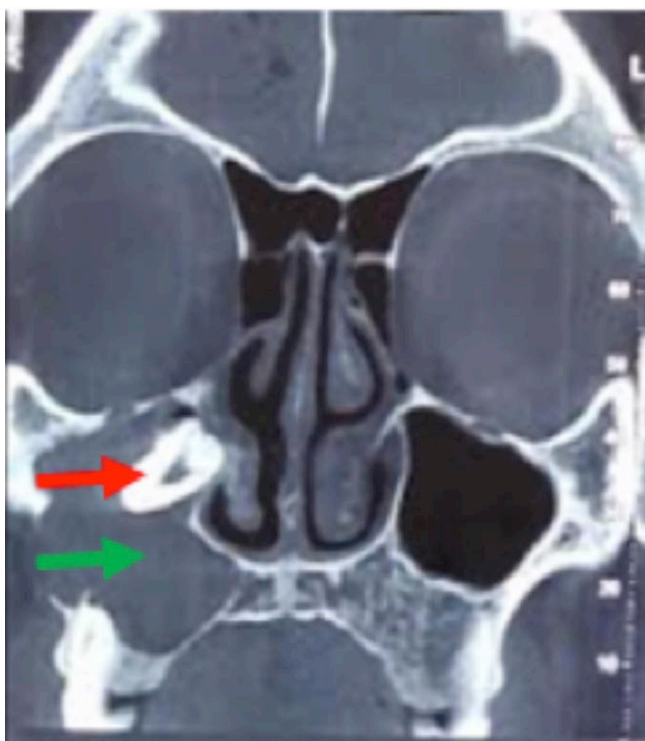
Facial CT, coronal section, bony window showing an ectopic tooth impacted in the inner wall of the right maxillary sinus at the ostial level (red arrow) and total filling of fluid density (green arrow)
